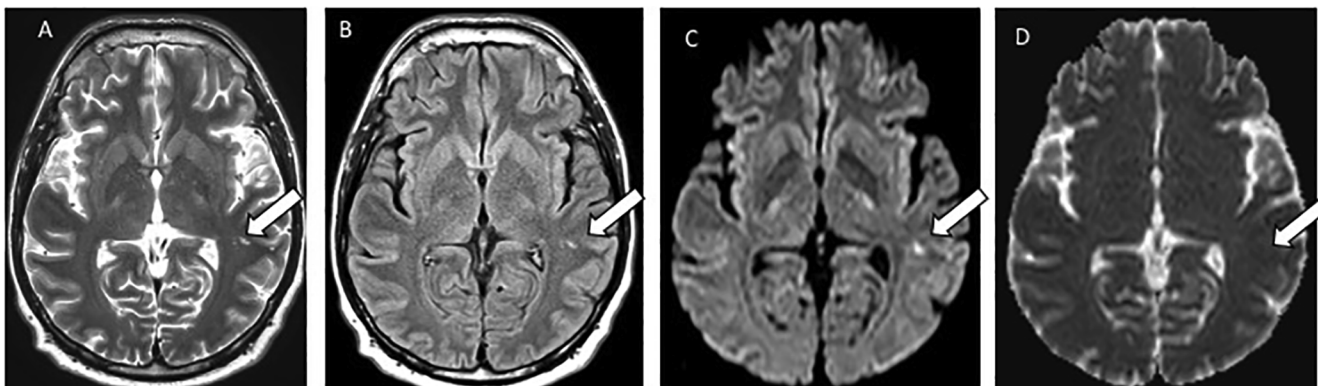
Case 1, MRI head 6 days after the onset of delirium: white arrows show the signal hyperintensity changes in the subcortex of the left lateral temporal lobe on T2-Weighted (A), FLAIR (B), and Diffusion Weighted Image (C), and ADC map (D).
